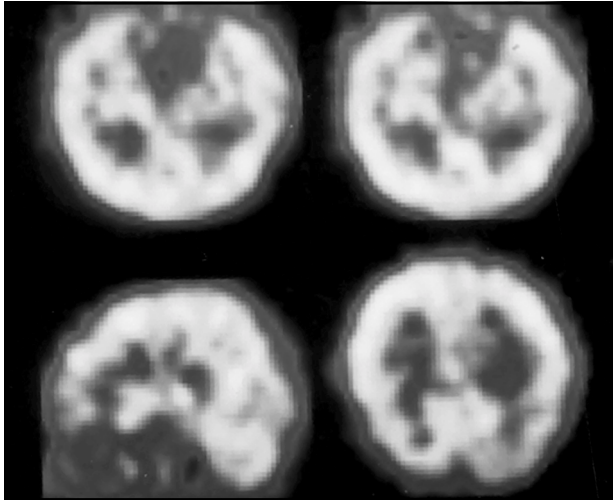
SPECT of Case 1. Superior half of the temporal axis: perfusion of the temporals. Sagittal inferior axis to the left: homogeneous and normal perfusion of the brain cortex and other structures. Inferior transversal axis to the left: homogeneous and normal perfusion of the brain cortex.
